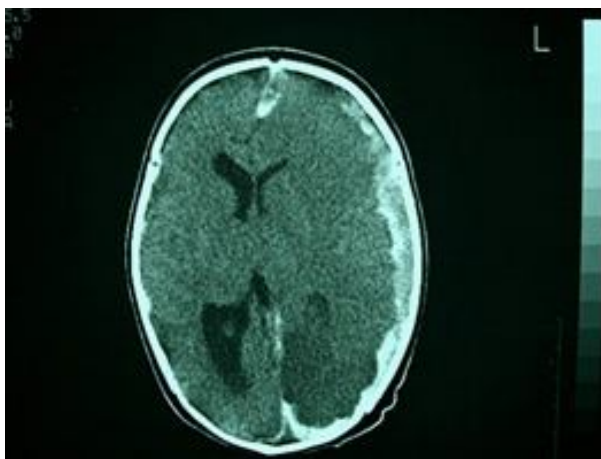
Cranial CT scan of a patient with subdural and subarachnoid hemorrhage, ventricular compression, midline shift and hemispheric edema.
